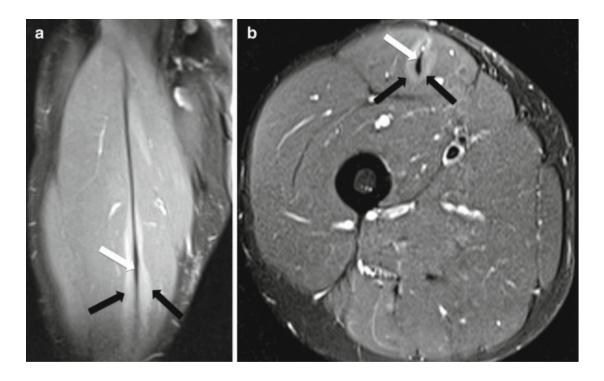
A 23-year-old male athlete with a fibrous scar of the rectus femoris deep tendon. (a) Coronal and (b) axial fat-suppressed T2-weighted MRI show thickened and hypointense deep tendon (*white arrows*) surrounded by increased signal intensity consistent with edema (*black arrows*)
